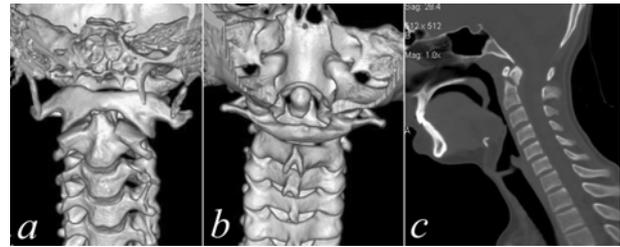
Type II dens fracture non-union 22 months postinjury before treatment. a, b – CT 3-D reconstruction; c – fine-cut helical CT
